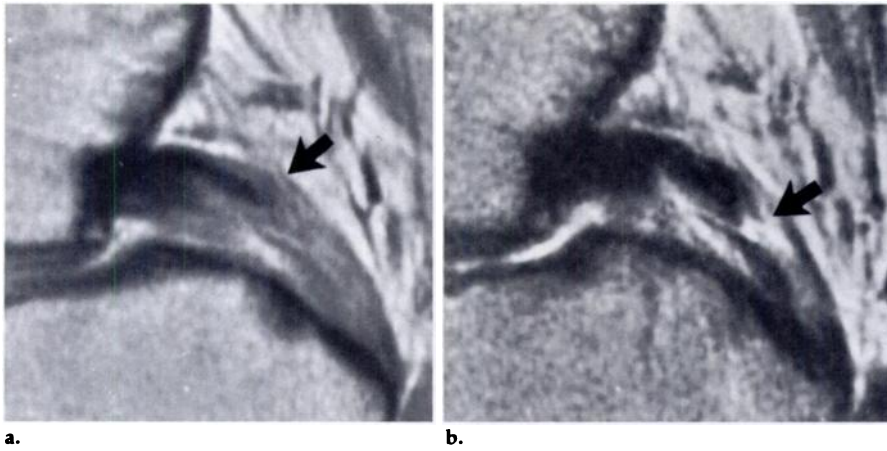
MR images of a 19-year-old man injured in a baseball game show a tear at the midportion of the PCL. There were no clinical findings of posterior laxity at either initial physical examination or at examination with the patient under general anesthesia. (a) Sagittal T1-weighted image shows an anatomic disruption of the ligament (arrow) and abnormally high signal intensity in the ligament. (b) Sagittal T2-weighted image shows high signal intensity fluid traversing the tear (arrow) in the ligament. A tear of the midportion of the PCL was confirmed at arthroscopy.
